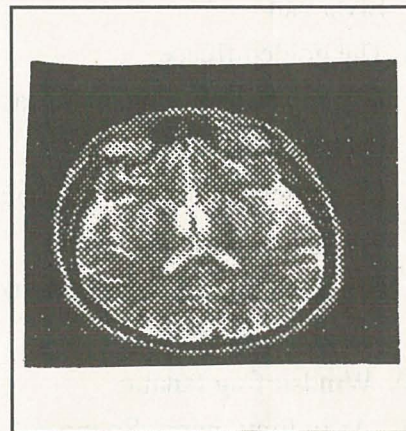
An MRI section through the brain of a patient affected with Creutzfeldt-Jakob disease. Found at the Whole Brain Atlas.
